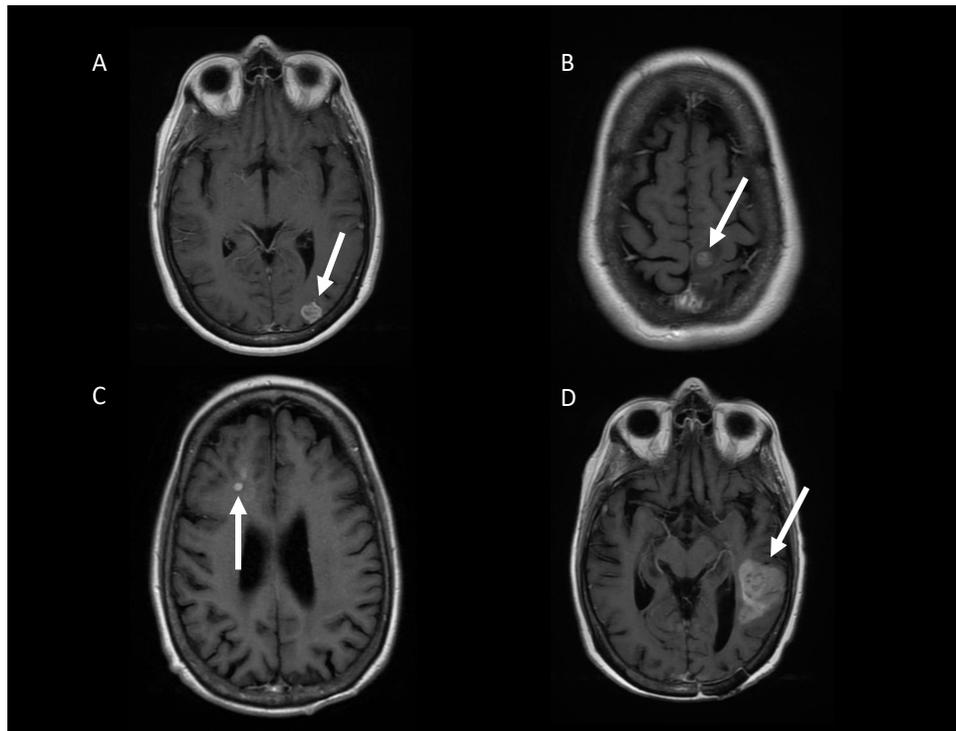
Axial post-contrast T1 MRI brain. (A) Original MRI showed enhancing lesion in left occipital lobe. This was treated with gross total resection. (B) Original MRI showed separate enhancing lesion in the left frontal lobe in the original MRI brain. (C) Surveillance MRI showed first recurrence in the right frontal lobe. Review of prior radiation map showed that this area was outside of the radiation field. This lesion was treated with gross total resection. (D) Surveillance MRI showed second recurrence in the left temporal lobe. MRI, magnetic resonance imaging.
